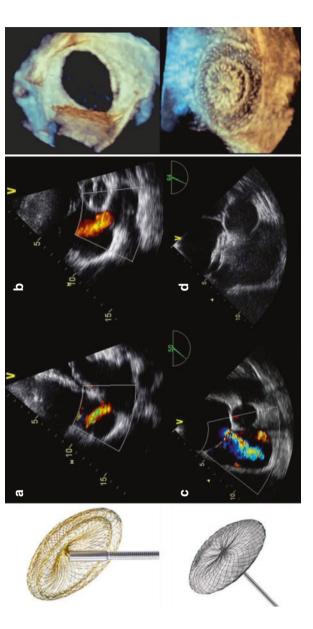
Transcatheter ASD closure is most commonly performed with the Occlutech® and Amplatzer Septal Occluder® (left-sided panel). Transthoracic and transoesophageal echocardiography of an ASD (a-c) is performed to assess the defect and control device placement (d). 3D echocardiography of the defect before and after device implantation (right-sided panel) Many ASD patients report few symptoms, but there is a favourable impact of ASD closure on exercise tolerance irrespective of age [11, 12]. Improved left ventricular filling with improved systemic cardiac output seems the likely mechanism by which ASD closure improves exercise capacity [13]. Cardiac reverse remodelling with reduction in right atrial and right ventricular volumes occurs soon after ASD closure and is more pronounced and often complete in younger patients [14]. Complete normalisation in right heart size cannot be expected in older patients following ASD closure—another argument for timely closure of ASDs earlier in life [15].
